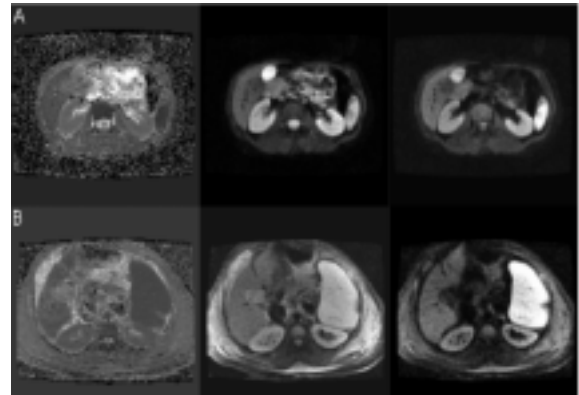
D map, $b=0$ reference images, and $b=300$ DWI scans in patients with normal (A) and elevated (B) Cr.
